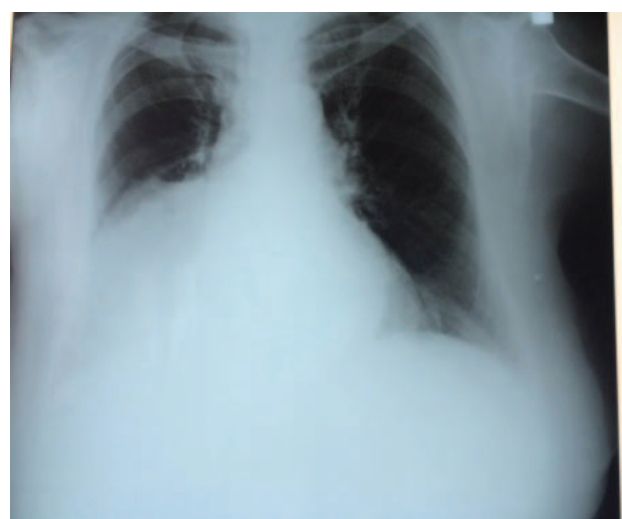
A posteroanterior chest radiograph shows an abnormal soft tissue opacity obscuring the right cardiac margin.
